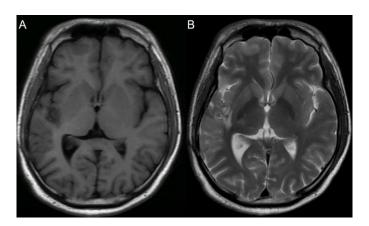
One year after the second operation, MRI images show no mass in the right sylvian fissure: MRI-T1 weighted image, axial view (A), MRI-T2 weighted image, axial view (B).
